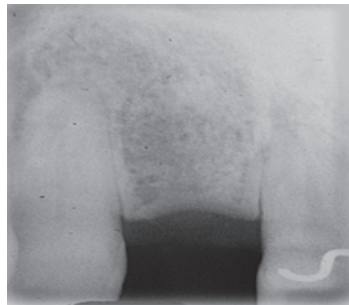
Preoperative periapical radiographic
